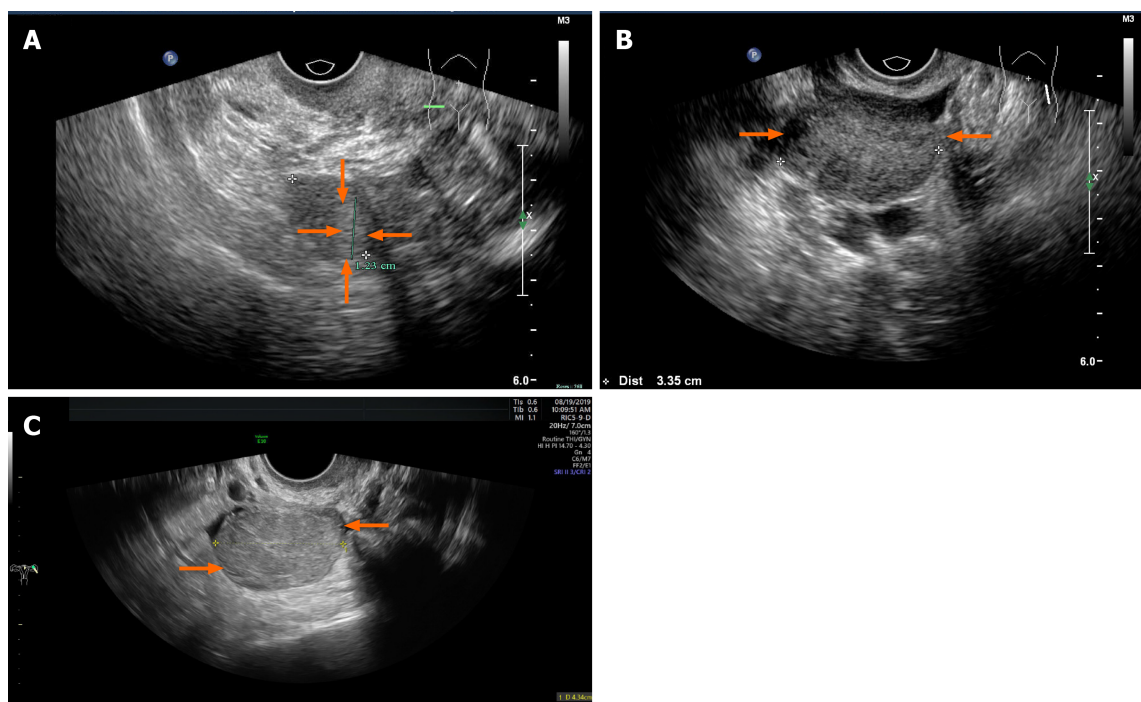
Transvaginal ultrasonography. A: A slightly hyperechoic nodule with an unclear boundary in the right ovary (case 1); B: The left ovary showed a slightly hyperechoic mass with clear boundary (case 2); C: A solid, slightly hyperechoic mass with clear boundary in the left ovary (case 3).
